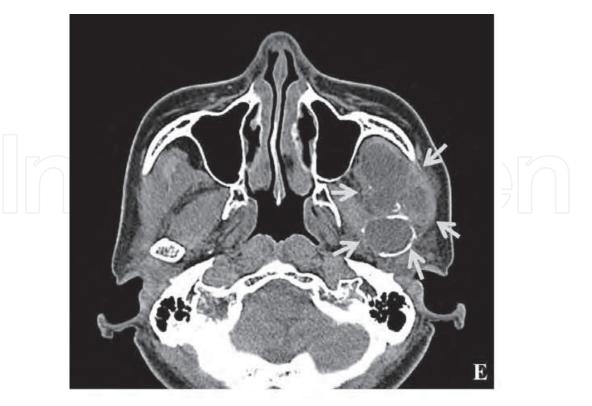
Panoramic radiograph image (A) and axial (B), oblique sagittal (C), oblique coronal (D) CT images of an ameloblastoma in the right mandible. Axial CT image (E) of a malignant ameloblastoma (arrows).
